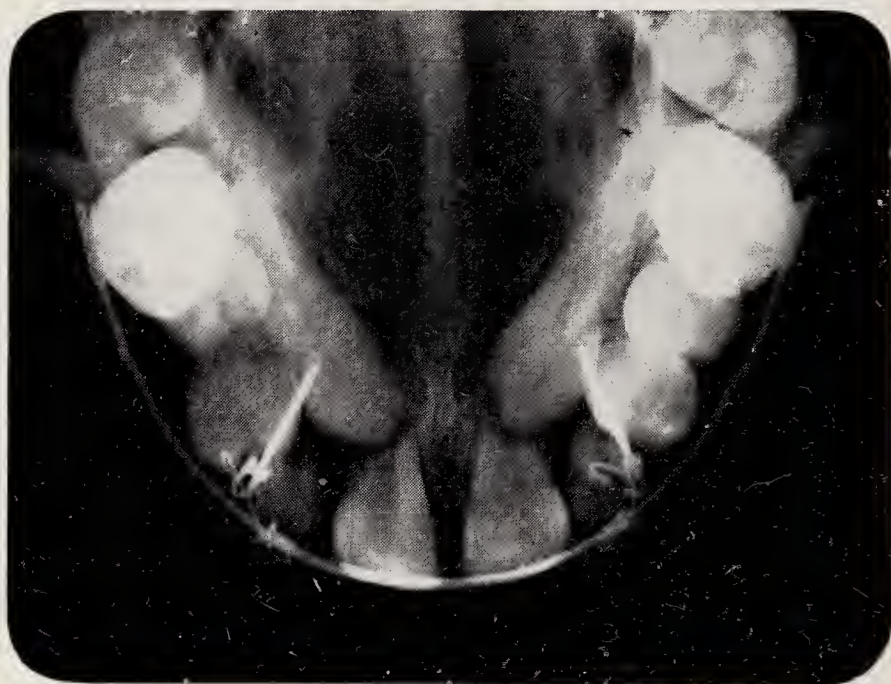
Radiographs to show extensive resorption of $\underline{1|1}$ associated with the impaction of $\underline{3|3}$. Patient, aged 12 years, had congenital absence of $\underline{2|2}$. Occlusal radiograph shows apparatus in position with pins inserted from buccal approach. Further radiographs show condition after $\underline{3|3}$ had been moved into position. There had been a continuation of resorption of $\underline{1|1}$. Both teeth are vital.
